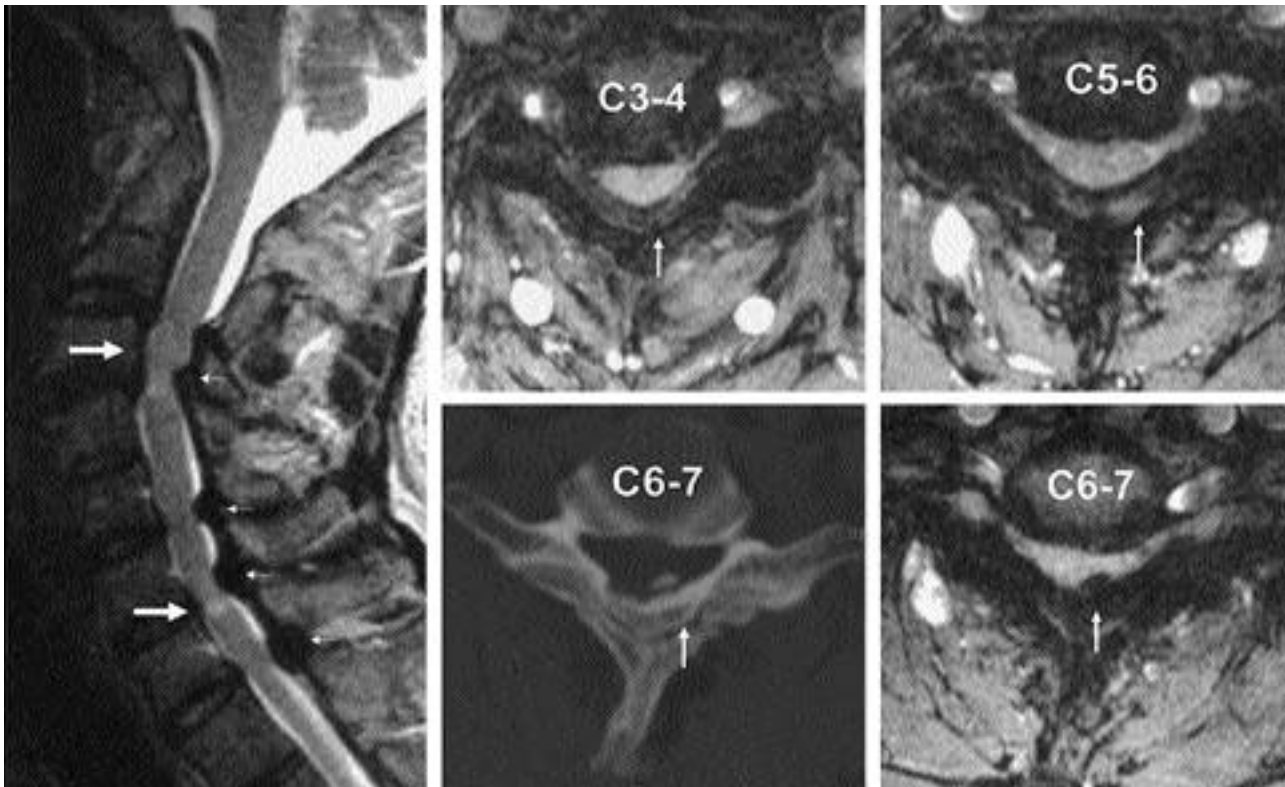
T2 sagittal MR image shows high signal intensity lesion in the cord (Large arrow) with compression of spinal cord by ossified yellow ligament (small arrow). T2 axial MR image and CT scan show compression of spinal cord by hypertrophied yellow ligament with ossification.
